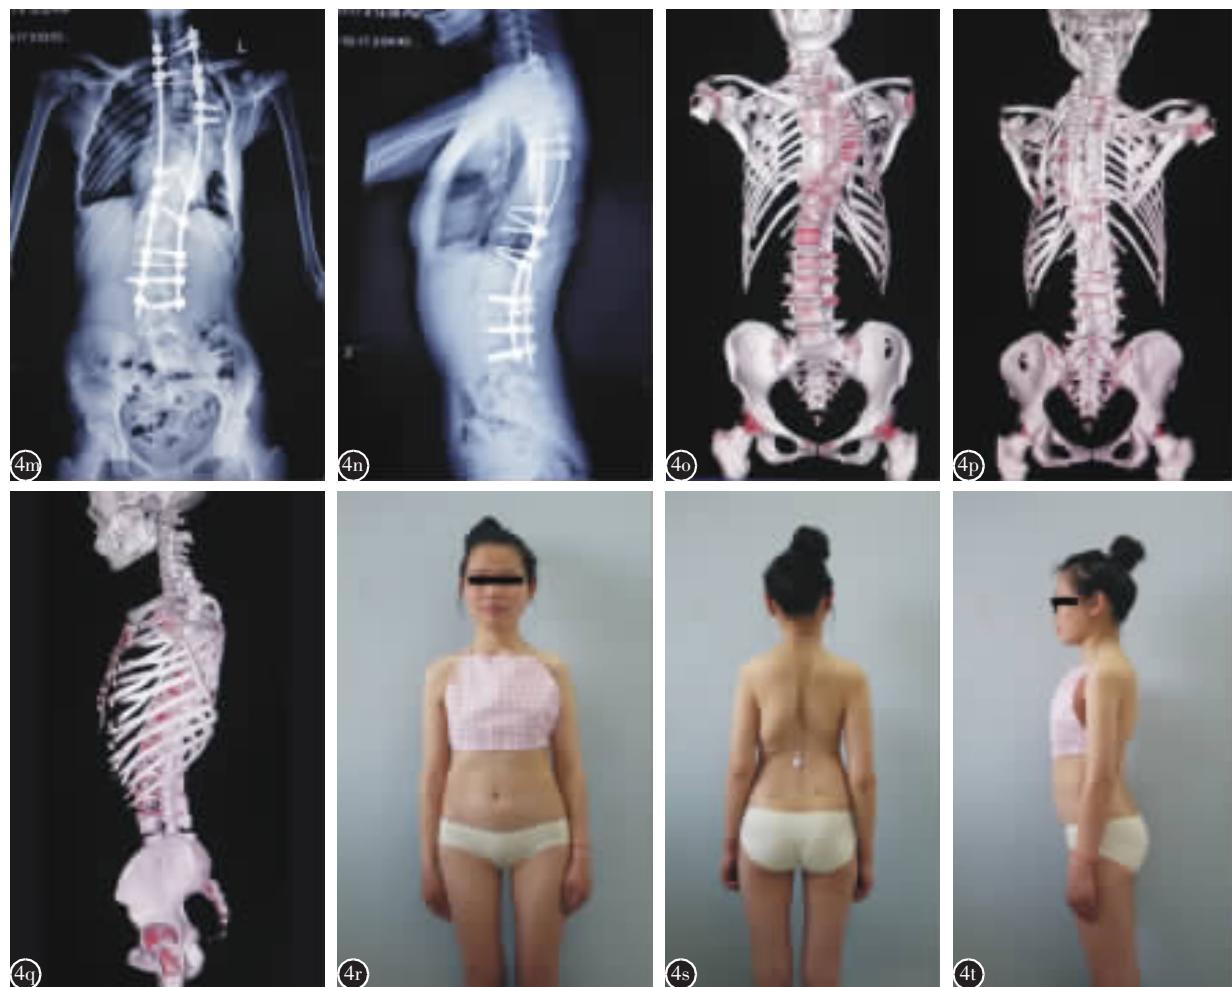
m 术后 27 个月正位 X 线片示 Cobb 角 43°, 矫正率 70.1%, 冠状面平衡 n 术后 27 个月侧位 X 线片示胸椎后凸 42° o~q 术后 27 个月脊柱 3D-CT 显示新生肋骨形成, 胸廓无扭转 r~t 术后 27 个月大体像侧后凸矫正, 躯干平衡
